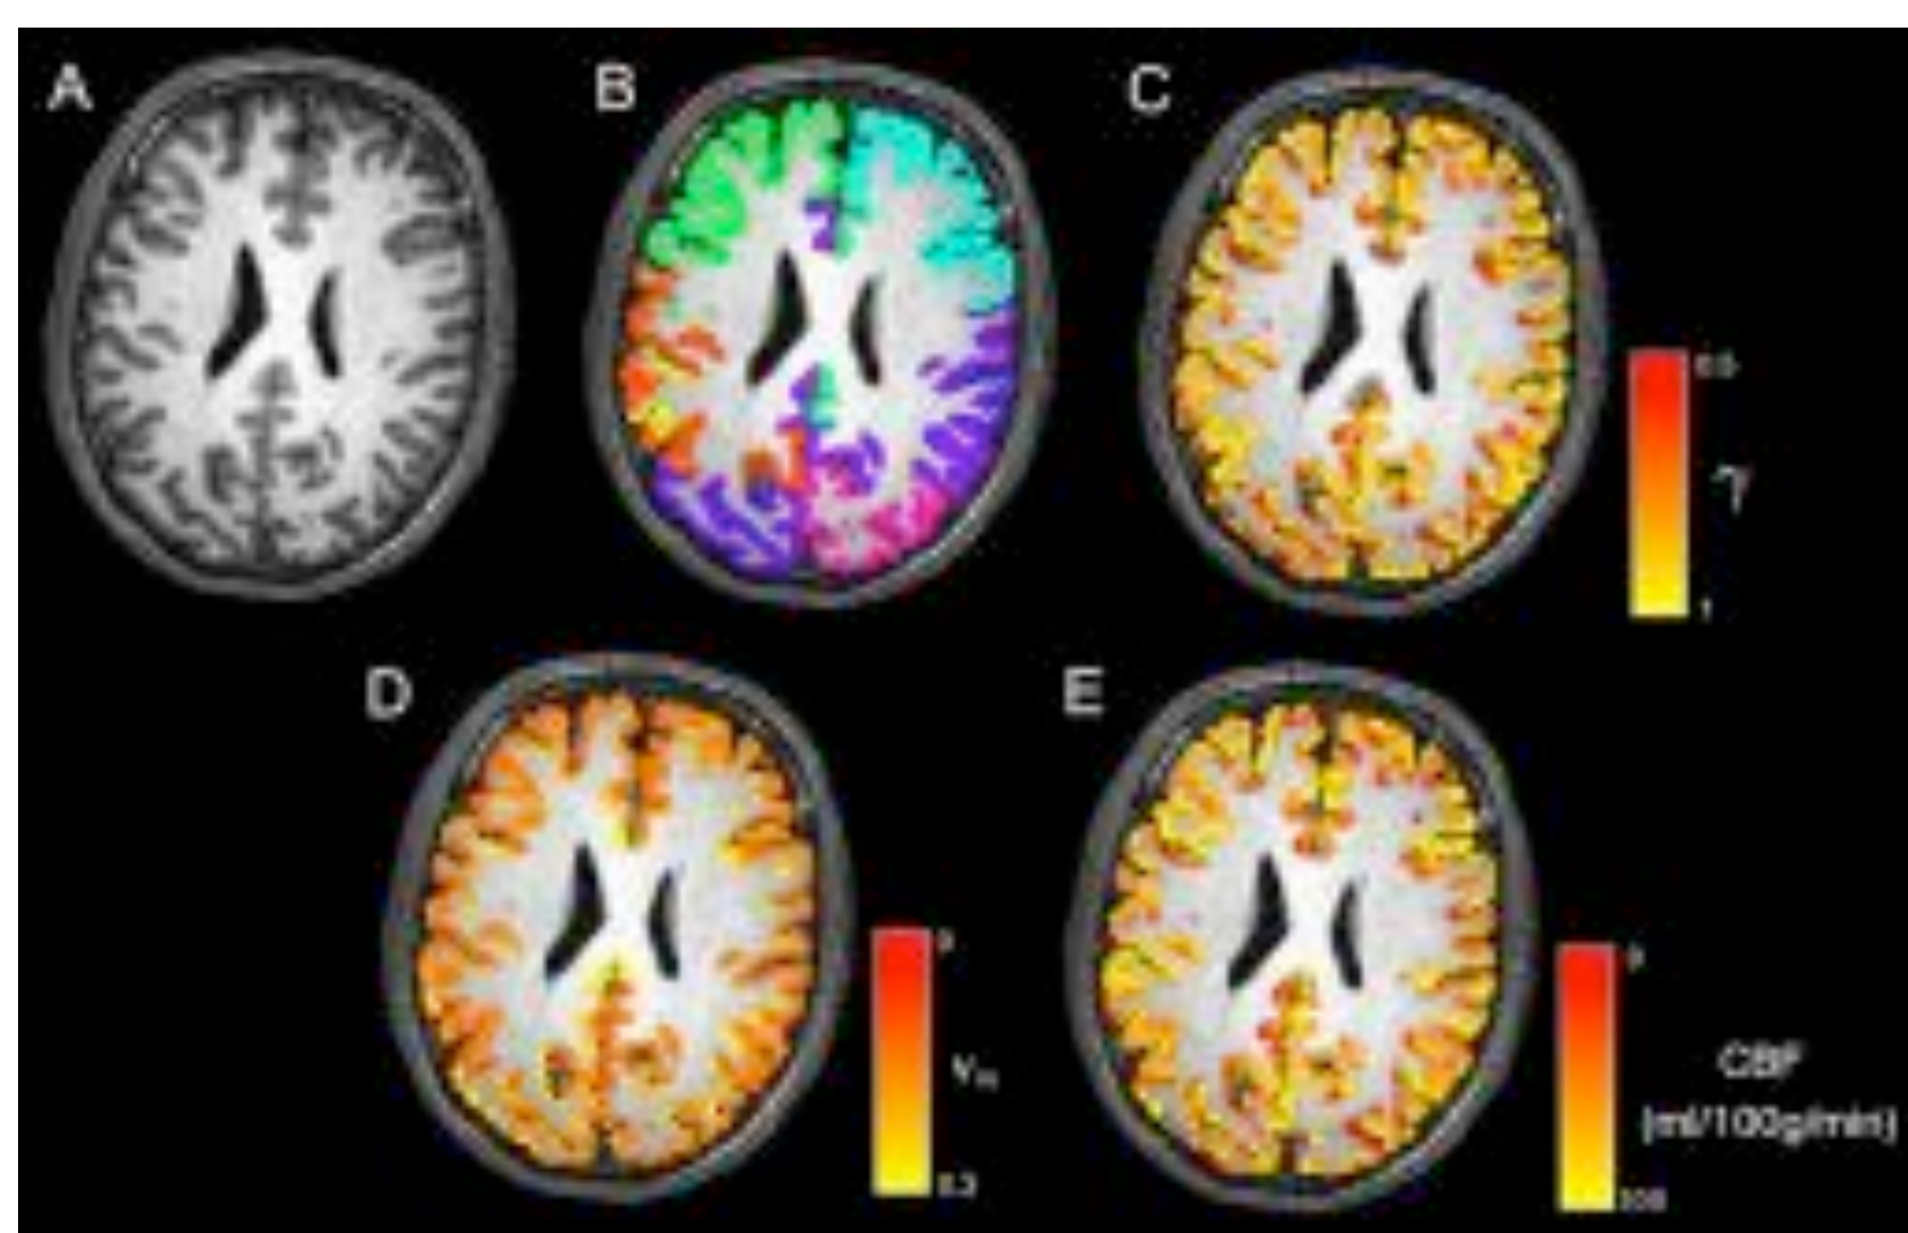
Single subject example: A) T1-weighted imaging, B) cortical parcellation, C) neurite orientation dispersion, D) intra-axonal volume fraction and E) cerebral blood flow.
